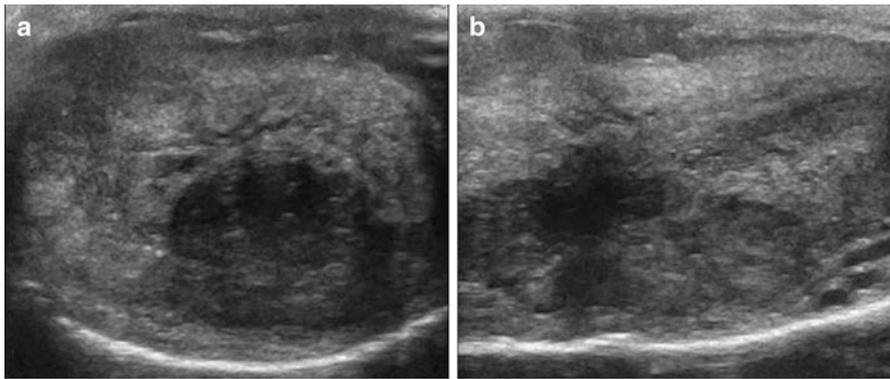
Heterogeneous penile tumor visualized transversely (a) and longitudinally (b) on penile Doppler ultrasound
